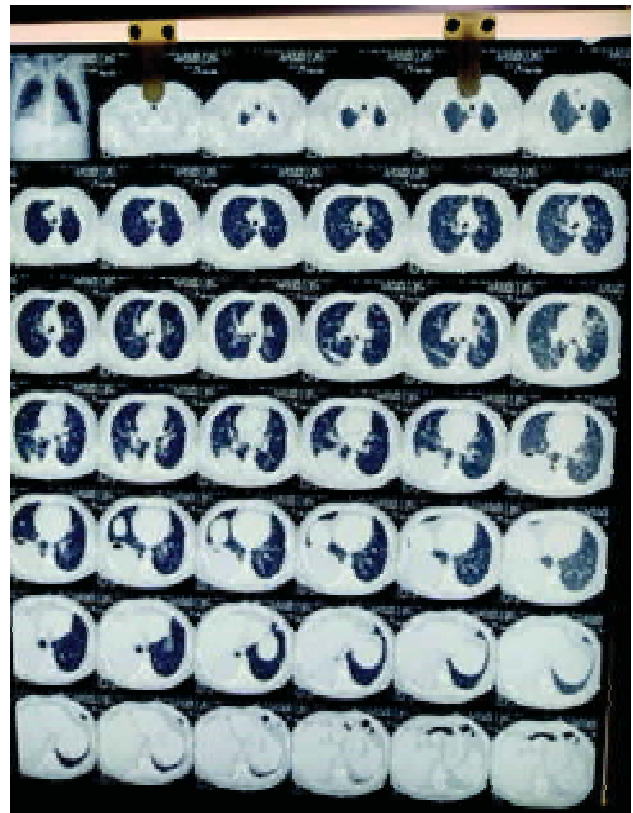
Pre-procedural CT scan.
